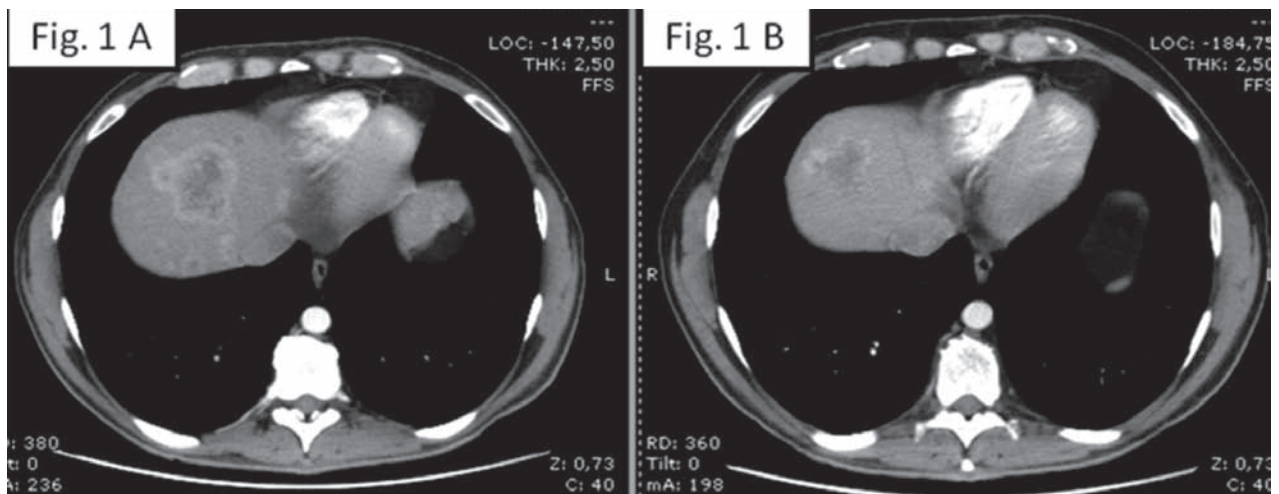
Abdominal CT scan in arterial phase before (A) and after (B) treatment with temozolomide showing partial response (PR) of liver lesions.
